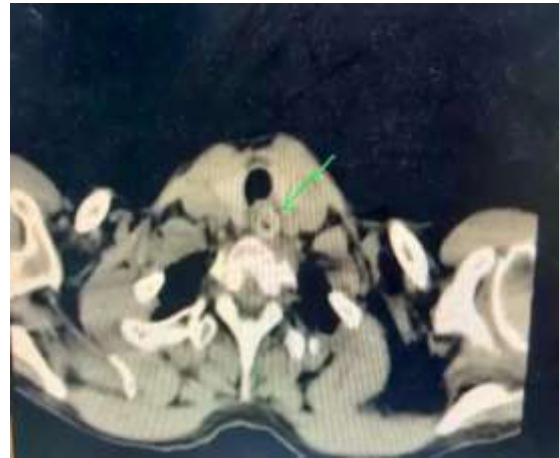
Axial CT showing the location of the foreign body
